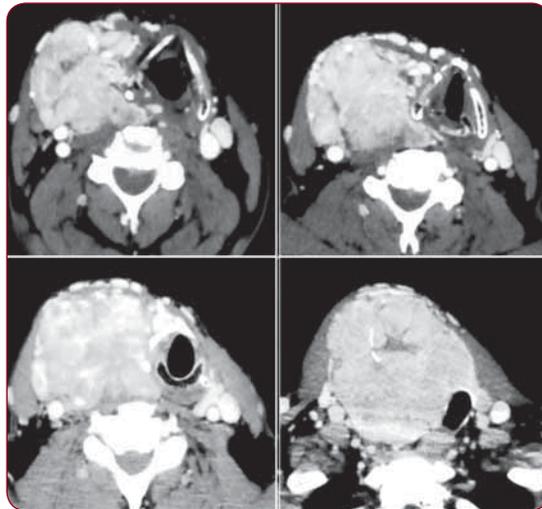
CT – A highly vascular thyroid tumor
